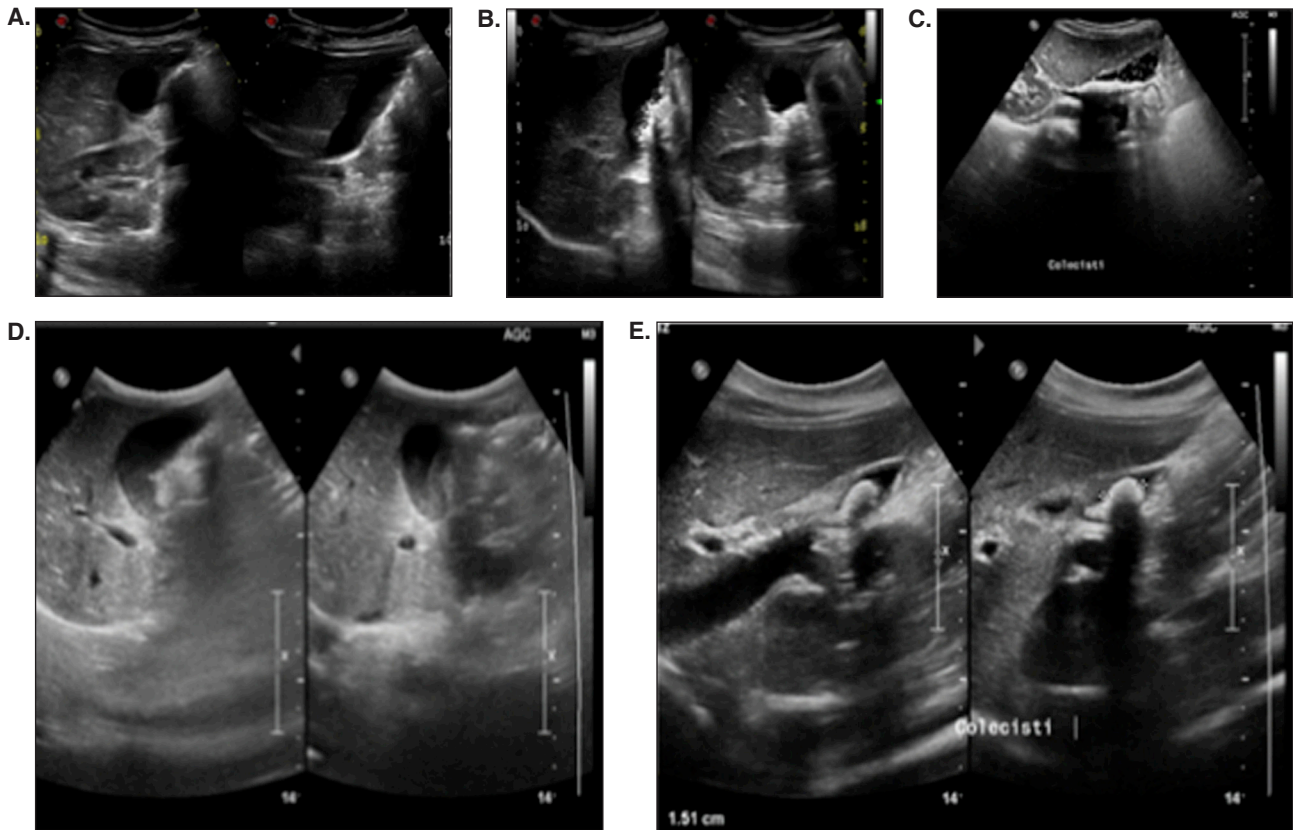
A. Case 2: abdominal ultrasounds (US) at hospital admission (before ceftriaxone treatment) shows a normal gallbladder. B-C. Case 2: abdominal US during ceftriaxone treatment shows gallstones of about 2 and 5 mm (B) and biliary sludge (BS) (C), respectively. D. Case 3: BS. E. Case 4: BS.
